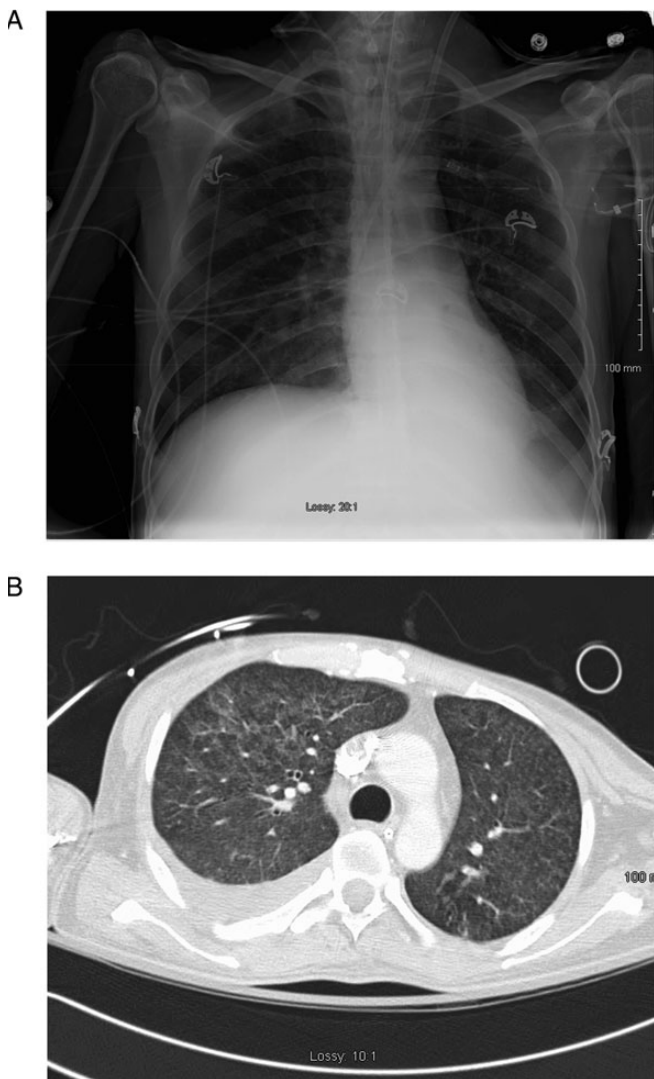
Chest X-ray and CT of the chest without contrast 2 weeks after initiating anti-tuberculous therapy demonstrating significant improvement in micronodular disease.
